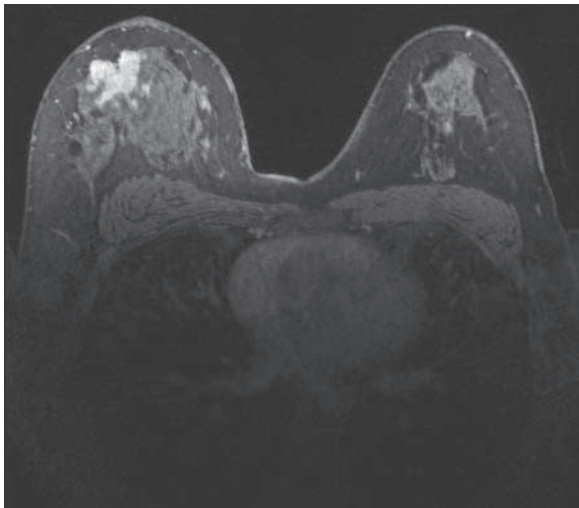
MRI of invasive breast cancer (*left half of figure*)
